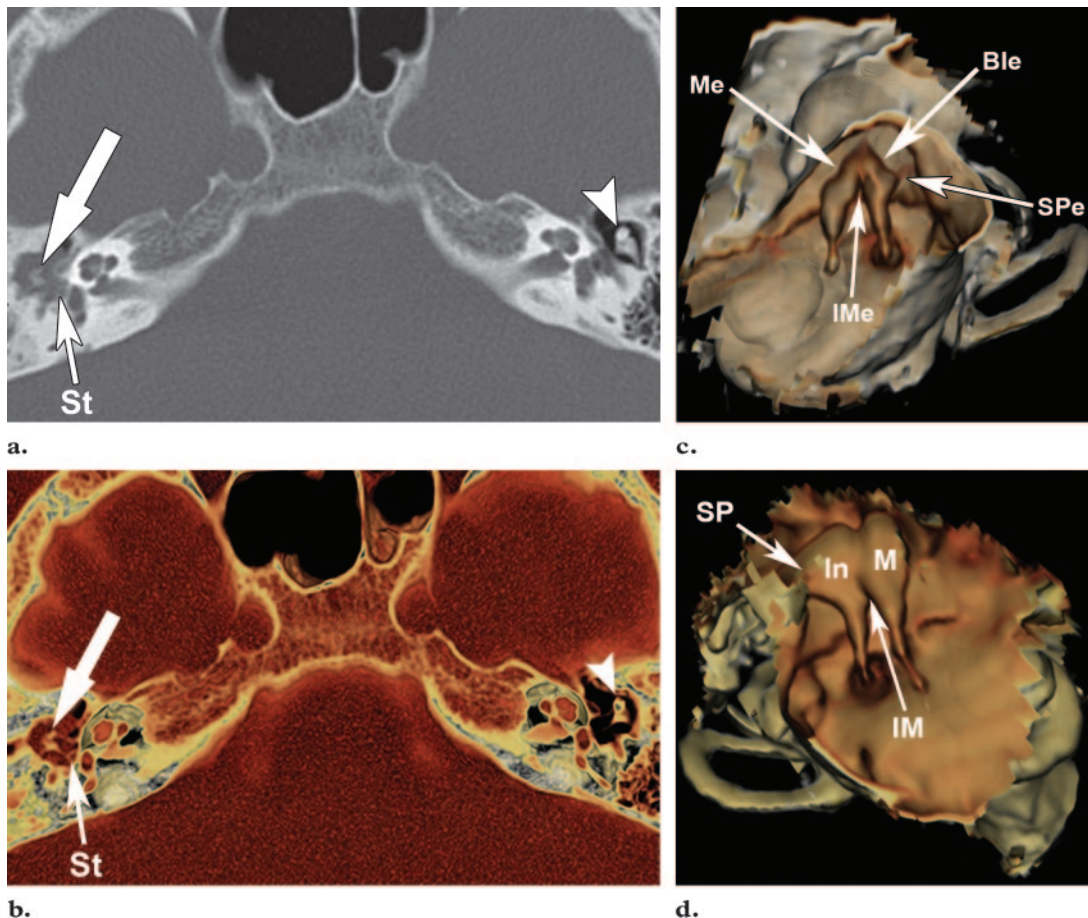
Cholesteatoma in a 26-year-old woman with right-sided hearing loss. (a, b) CT scan (a) and corresponding 3D CT reformatted image (b) show erosion of the right malleus and incus (arrow). The stapes (*St*) is intact and is better appreciated on the 3D image. The left malleus and incus (arrow-head) are normal. (c) Three-dimensional VR CT image (lateral view after dissection of the anteroinferior portion of the EAC) shows pressure erosion of the head of the right malleus (*Me*) and the body of the incus (*Ble*), along with nearly complete erosion of the short process of the incus (*SPe*). Extension of the erosion into the incudomalleolar articulation (*IMe*) is also noted. (d) Three-dimensional VR CT image (lateral view after dissection of the anteroinferior portion of the EAC) shows the normal left side for comparison. *IM* = incudomalleolar articulation, *In* = incus, *M* = malleus, *SP* = short process of the incus.
